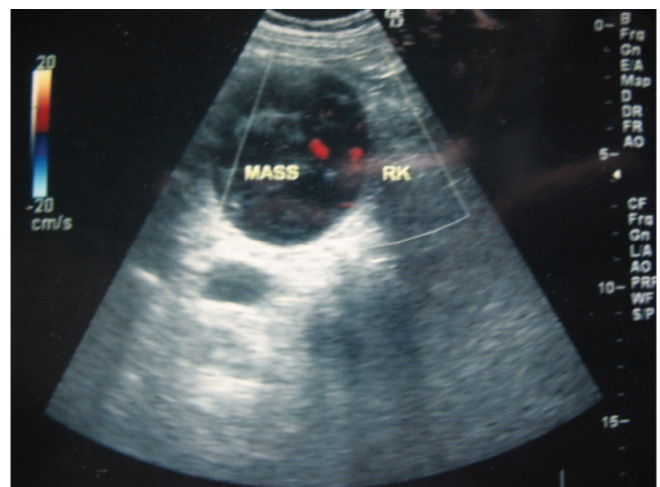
Ultrasound reveals a relatively hypoechoic mass with uneven internal echo and blood flow signal.
